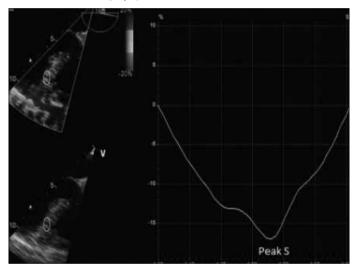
Mid septal segmental longitudinal strain analysis with transesophageal echocardiography
